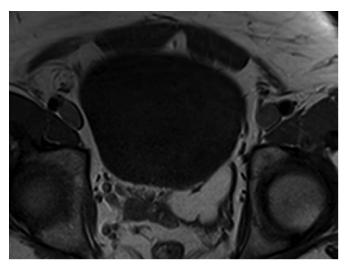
Preoperative pelvic MRI of the pelvis.
